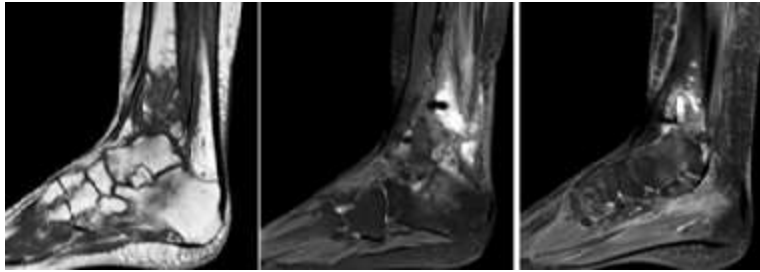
Right Ankle MRI of patient with septic arthritis and tibial distal osteomyelitis.
